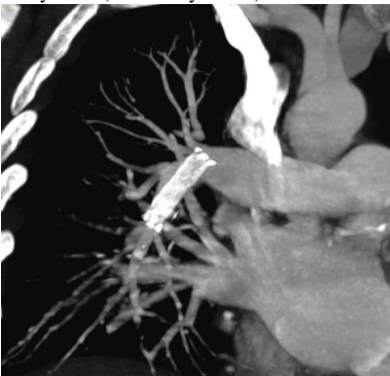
Computed tomography of the chest with migration of the stent in the right interlobar pulmonary artery.
